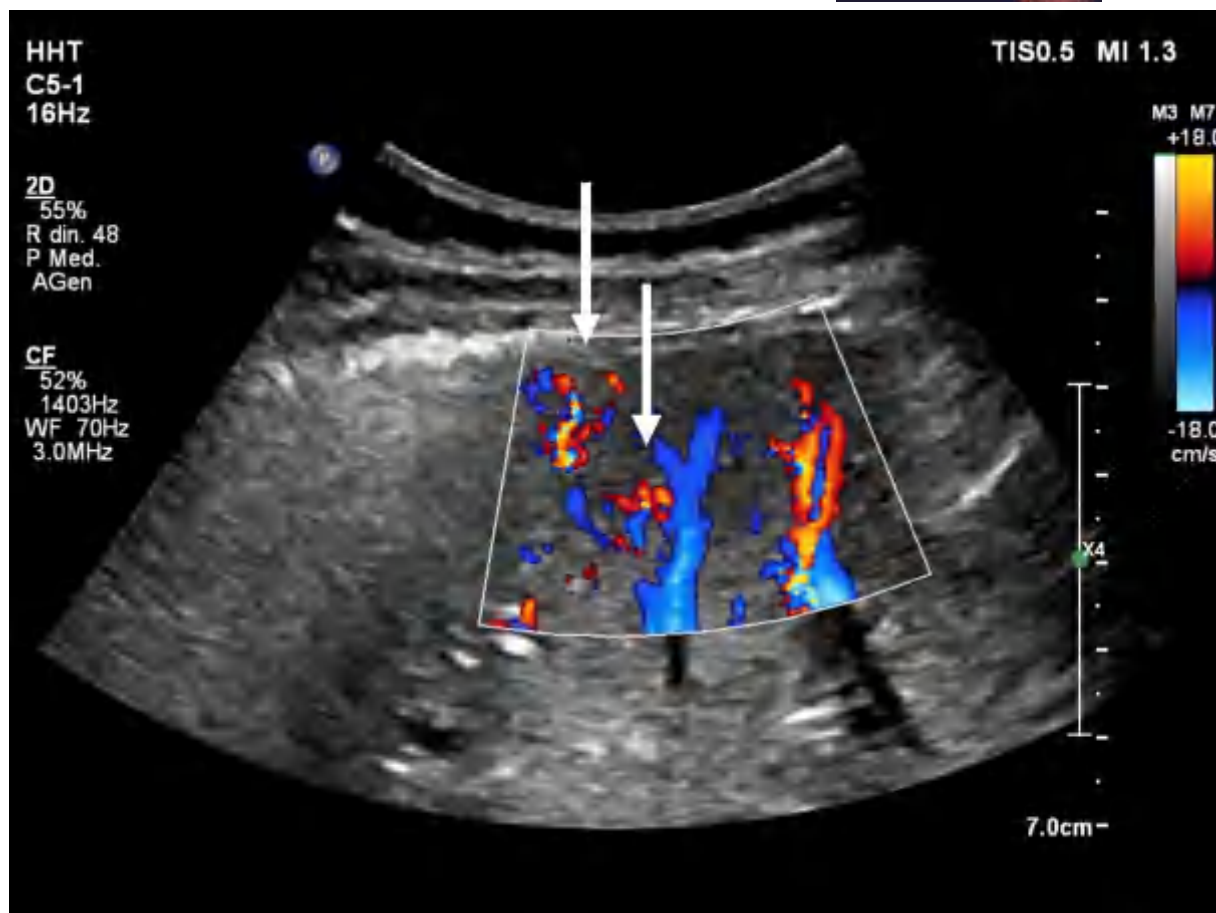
High-frequency colour Doppler study of the liver in a HHT patient can show the presence of multiple peripheral VMs (arrows).
